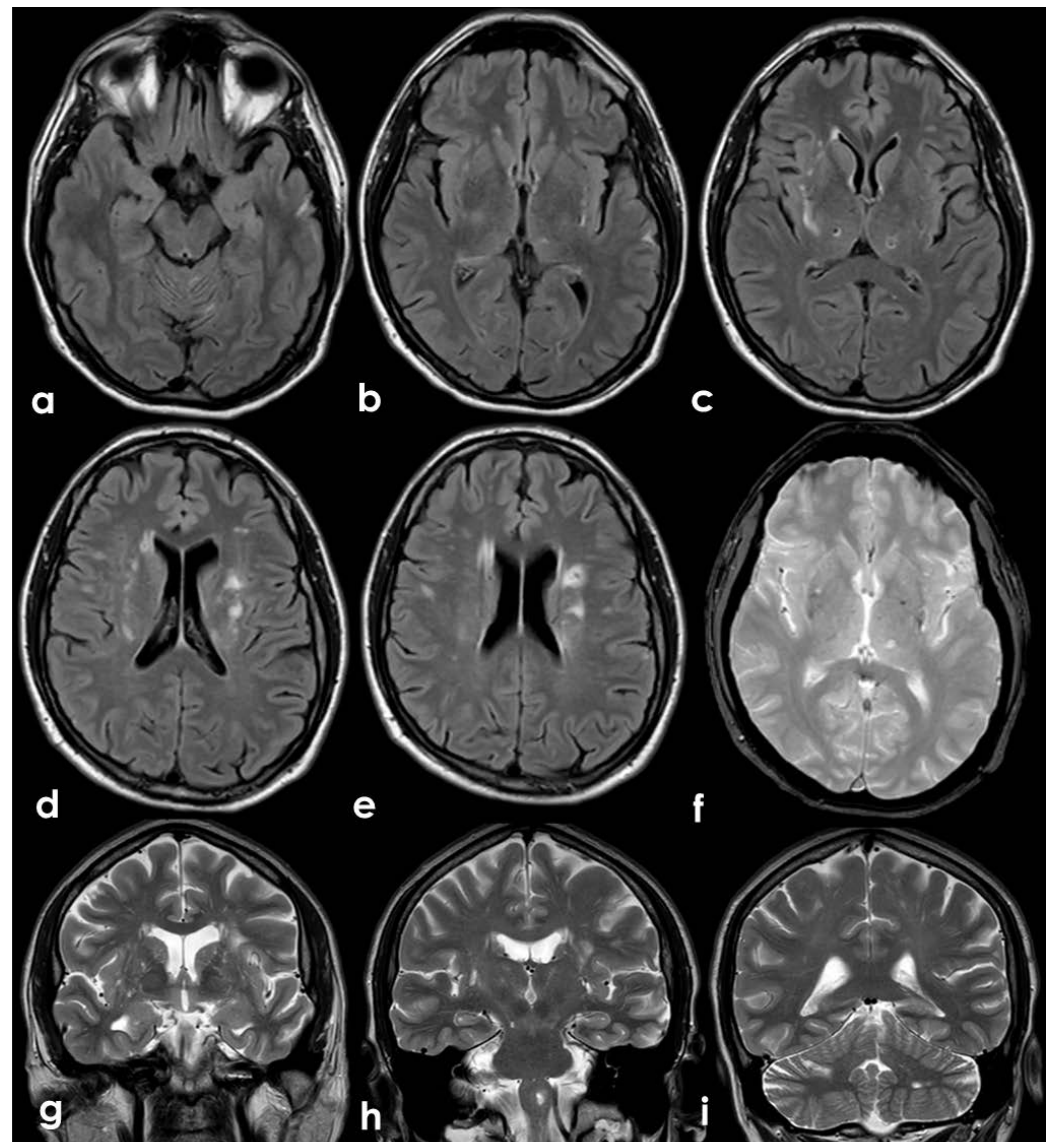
Brain MRI performed after 4 weeks from the admission. Axial FLAIR images (a-e) showing multiple white matter hyperintensities in the deep and subcortical location, (ie. centrum semiovale, external capsule) and few cavitating lesions in the posterior thalamus on both sides (b, c). In a and b also a focal cortical hyperintense lesion in the left temporal lobe is identified. Gradient Echo (GRE) sequences show a single deep small and rounded hypointense area (microbleed) and T2-weighted sequence images in coronal plane (g-i) show several enlarged perivascular spaces, mainly in basal ganglia on both sides.
